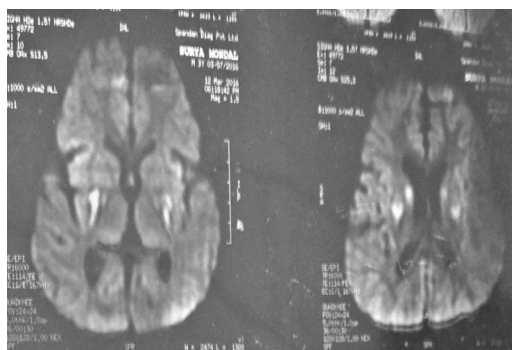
MRI T1 weighted image showing bilateral symmetrical hyperintensities in the basal gaglia and dentate nucelus region.
